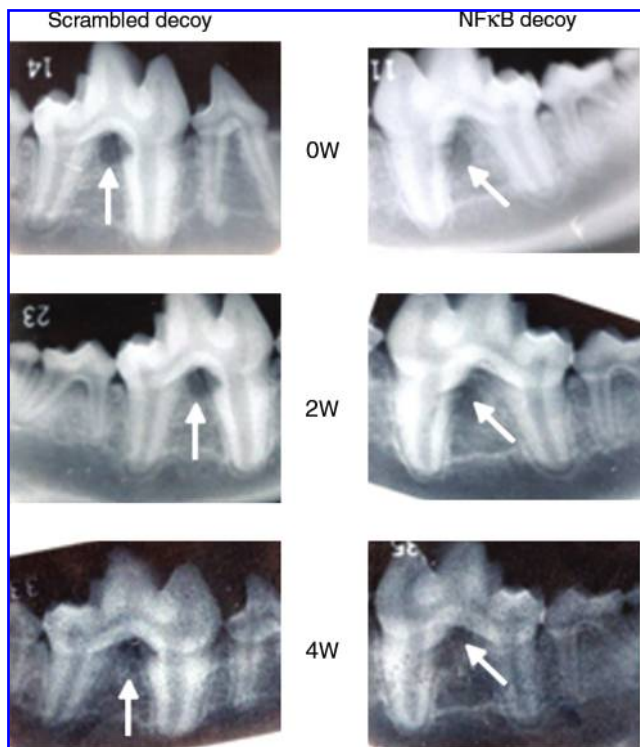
Representative views of the healing process of the bone-defect region in dental radiographic films at just after, and at 2 and 4 weeks (0, 2, and 4W) after surgery. Left line, scrambled decoy ODN-treated side; right line, NF- κ B decoy ODN-treated side. Defect areas are indicated with white arrows.
